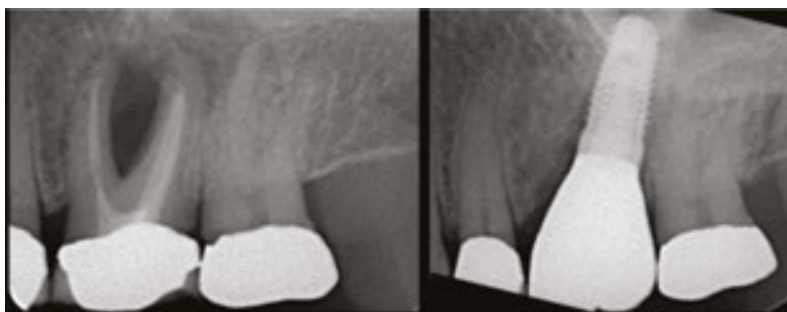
Before and after radiographs.
